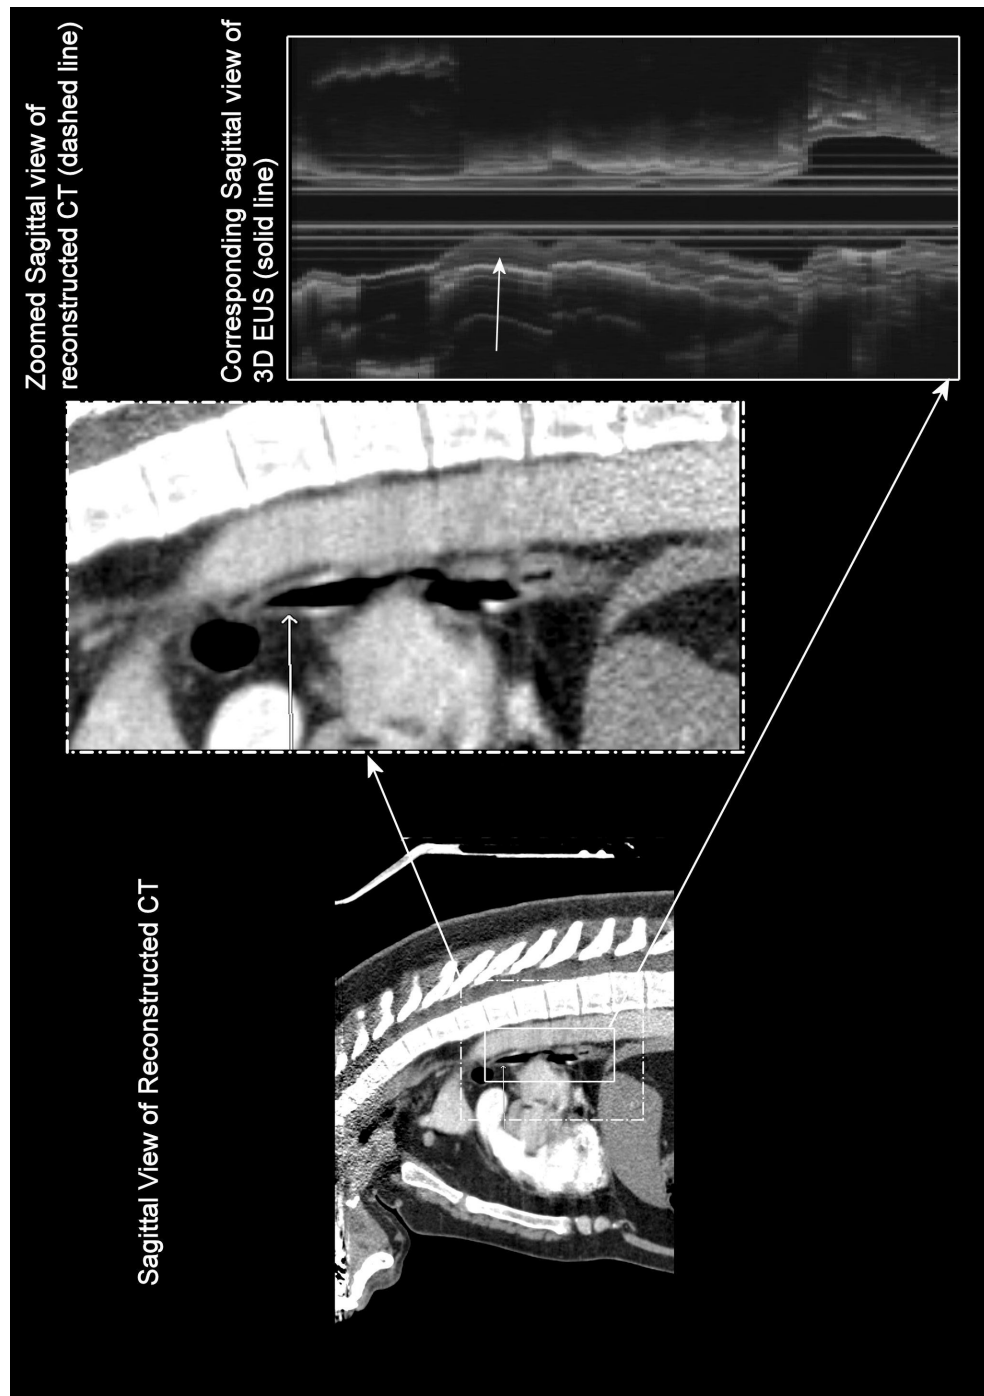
Comparison of sagittal views between CT and 3D EUS, the sagittal cuts of both CT and EUS. The EUS clearly shows an increase thickening of 6 mm associated with tumour infiltration. The CT did not show any detectable evidence of wall thickening in the sagittal view.
